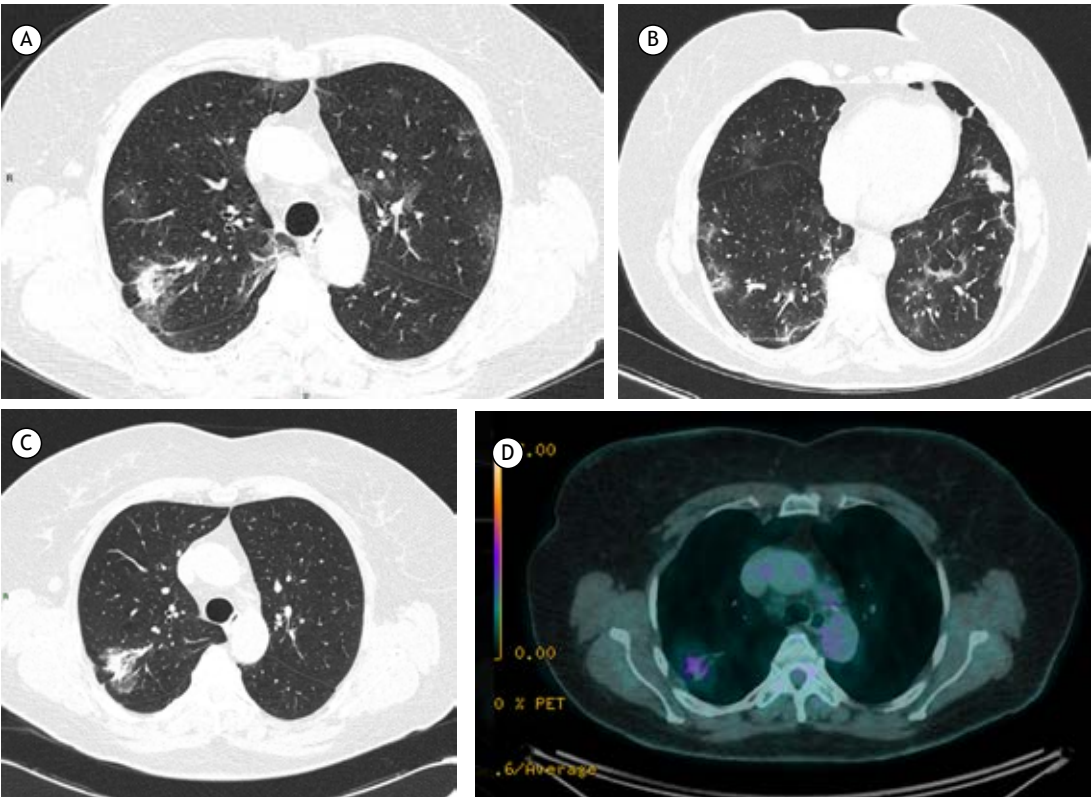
Chest CT scans. In A and B, part-solid nodule in the right upper lobe, as seen on the initial CT scan of a COVID-19 patient with pneumonia and other ground-glass and consolidative opacities. In C and D, part-solid nodule in the right upper lobe, as seen on the follow-up CT scan after regression of viral inflammatory lesions (in C), as well as FDG uptake on PET-CT scans (resected adenocarcinoma; in D).
